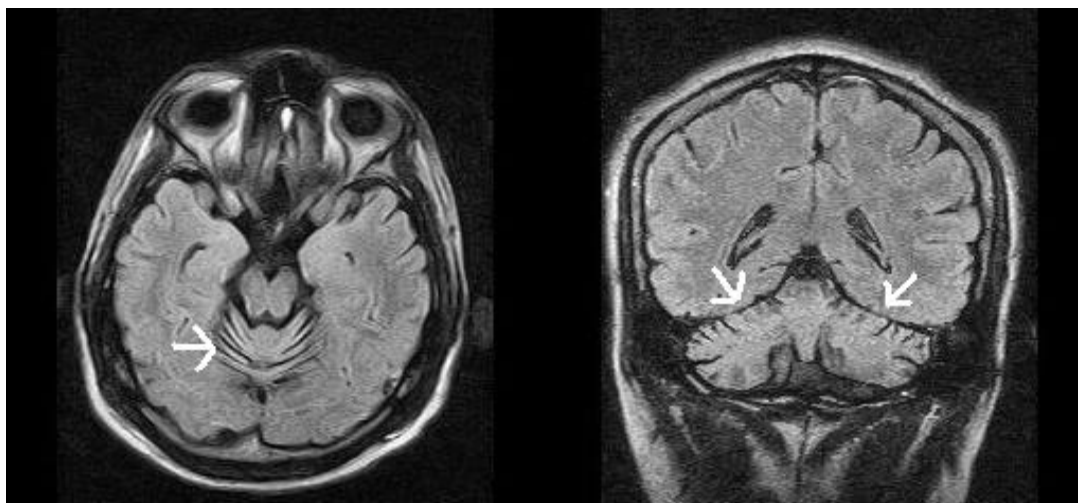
Magnetic resonance imaging (MRI) axial fluid-attenuated inversion recovery (FLAIR) (left) and frontal (right) FLAIR sequences showing prominent folia due to cerebellar atrophy
